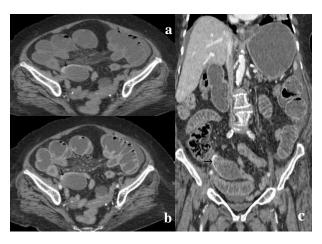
Case 2- axial unenhanced CT scan image (a) shows tubular cystic mass in right lower quadrant with curvilinear calcification (black arrows); (b) axial; and (c) coronal contrast-enhanced CT scan images show thin enhancing wall (white arrows) of lesion.
